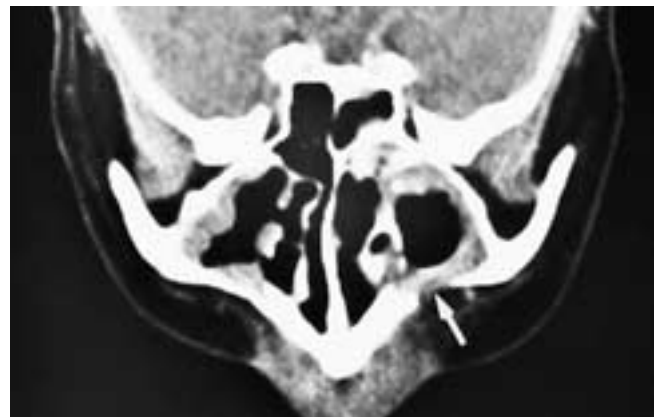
Coronal CT scan shows the Caldwell-Luc defect in the anterior left maxillary sinus wall (*arrow*) and inflammatory mucosal thickening in both antra.
